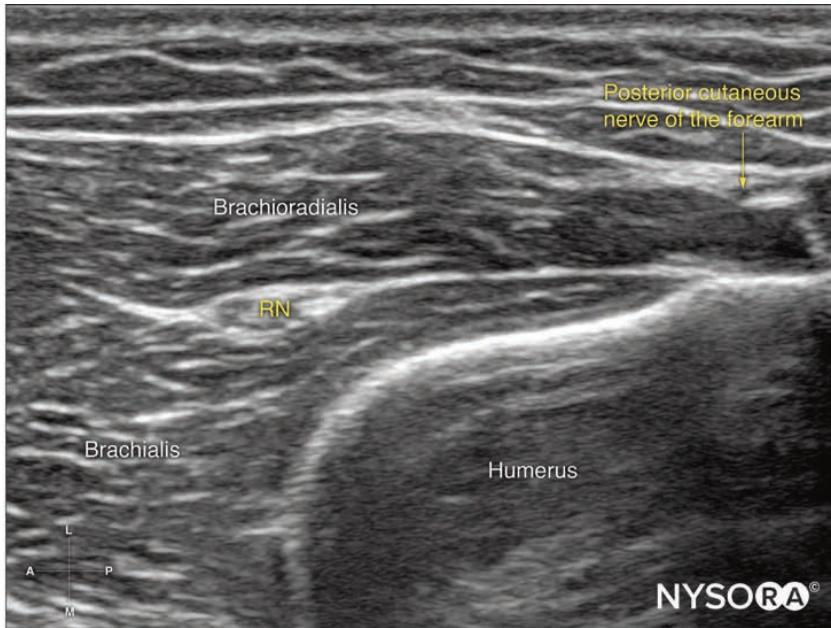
Probe position and ultrasound image of the radial nerve (RN) above the elbow.
